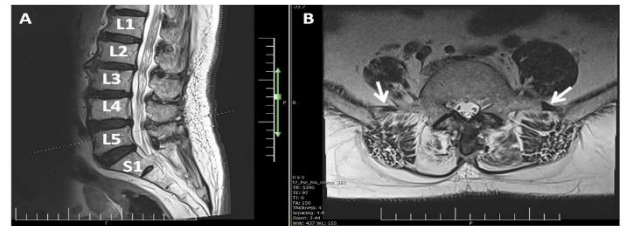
Sagittal T2W total spin MRI image shows normal numbering of spinal column without LSTV
